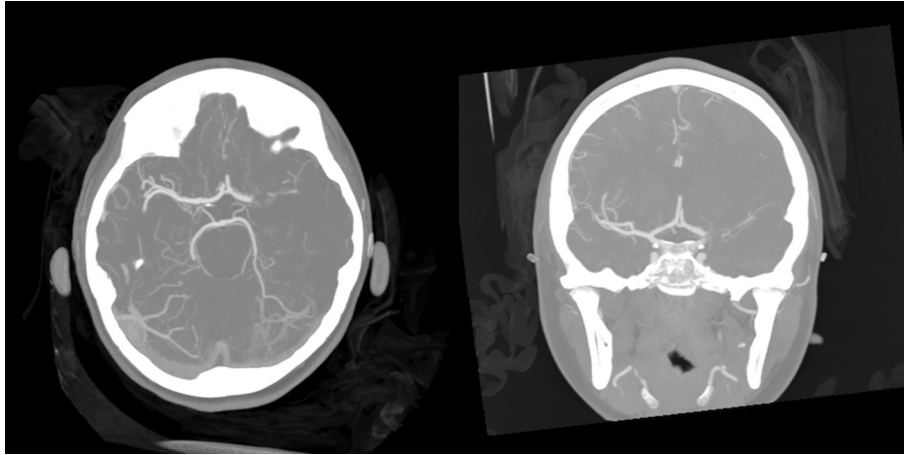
Axial and coronal computed tomography angiography demonstrating blockage of left middle cerebral artery and loss of distal flow.
